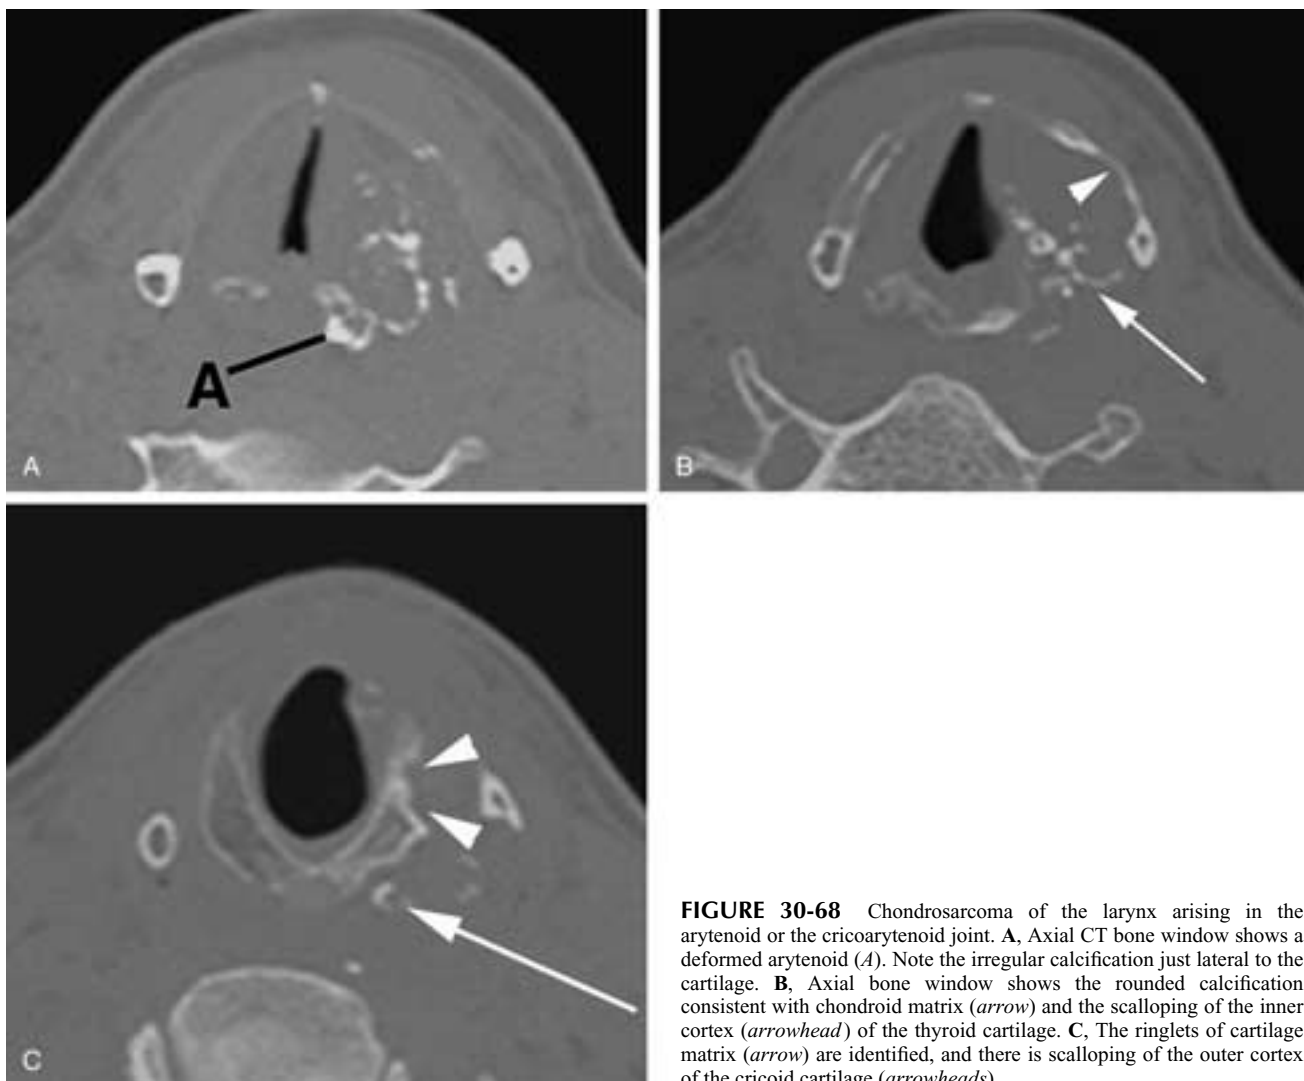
Chondrosarcoma of the larynx arising in the arytenoid or the cricoarytenoid joint. A, Axial CT bone window shows a deformed arytenoid (*A*). Note the irregular calcification just lateral to the cartilage. B, Axial bone window shows the rounded calcification consistent with chondroid matrix (*arrow*) and the scalloping of the inner cortex (*arrowhead*) of the thyroid cartilage. C, The ringlets of cartilage matrix (*arrow*) are identified, and there is scalloping of the outer cortex of the cricoid cartilage (*arrowheads*).
